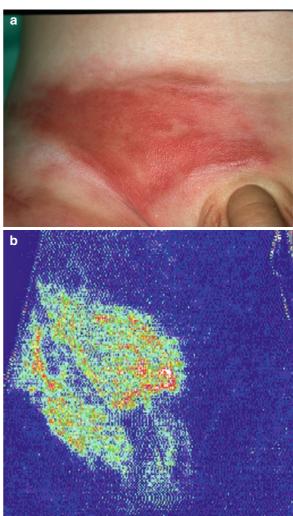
(a) Kaposi-like congenital hemangioendothelioma with "wasp sting symptom" reminiscent of a bacterial infection. (b) Detection of superficial hyperperfusion in the laser doppler imaging. (c) Magnetic resonance imagnig showing the depth of subcutaneous infiltration. (d) Only color-coded duplex sonography can demonstrate the pathognomonic pattern: interstitial hypersonic areas separated by hyposonic septa with palisade-like vessels
